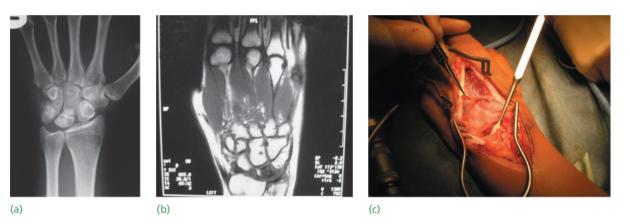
Kienböck's disease stage 1 (a) Not seen on X-ray; (b) seen on MRI scan; (c) treated by vascular bundle implantation.
